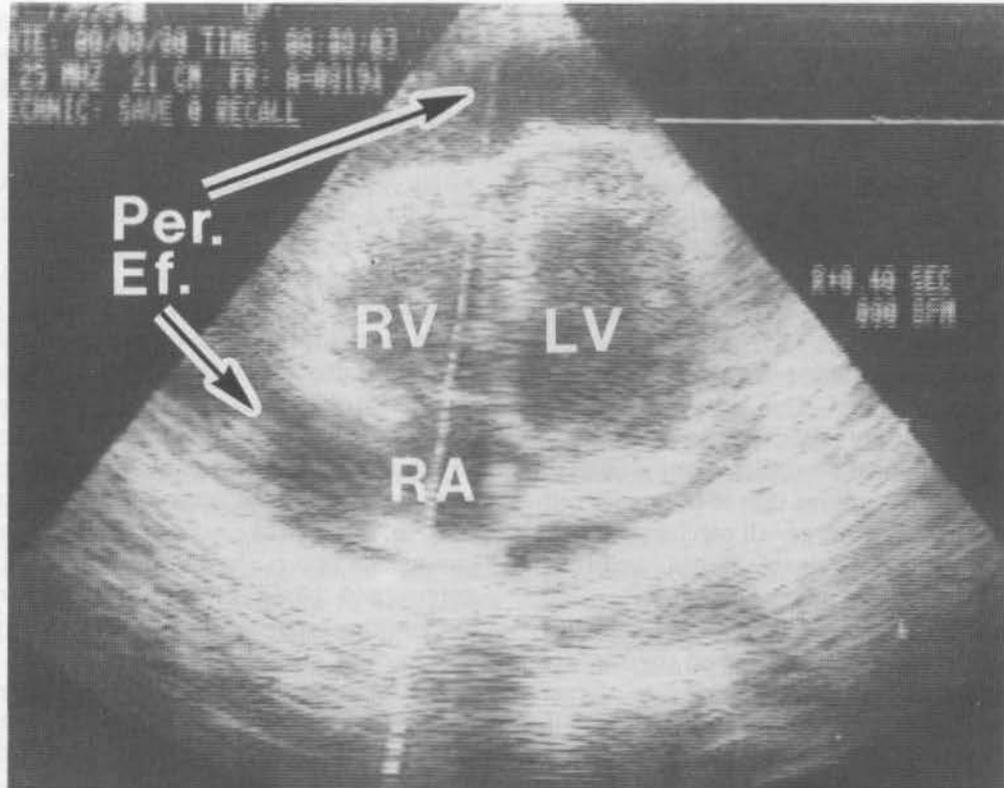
2-D parasternal long axis echocardiogram demonstrating large anterior and posterior pericardial effusions prior to pericardial tap (RV-right ventricle; LV-left ventricle).
